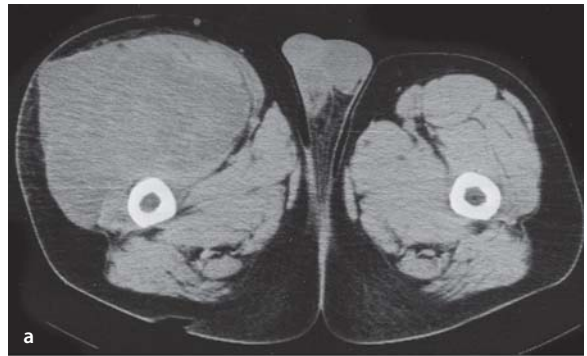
a, b. Liposarcoma of the thigh in a 68-year-old man. a Computed tomography (CT) scan. b After intravenous contrast medium. Mass arising in the right vastus intermedius muscle slightly hypodense to muscle on unenhanced CT (a) and irregularly enhancing after contrast administration (b)
